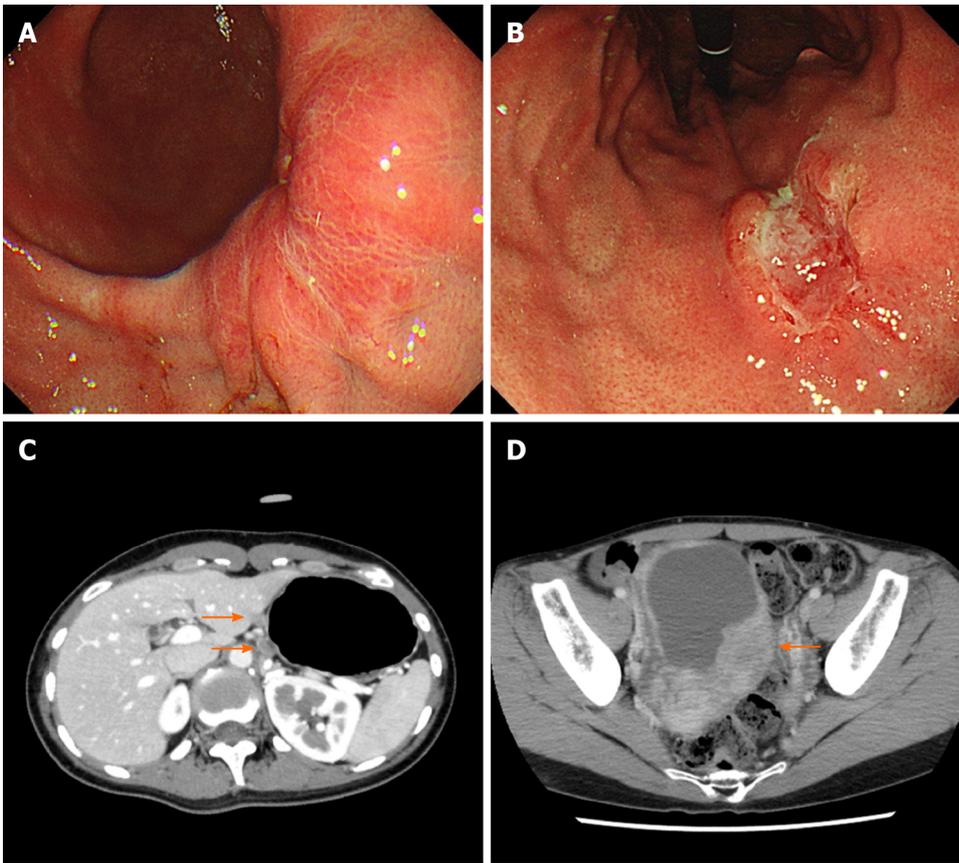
Representative images obtained from esophagogastroduodenoscopy and computed tomography in Case 1. A and B: Advanced gastric cancer was observed at the posterior wall of the lower gastric body (A) and at the lesser curvature of the middle body (B) in esophagogastroduodenoscopy; C: Metastatic lymph nodes were detected at the lesser curvature of the proximal stomach by abdominal computed tomography (CT) (orange arrows); D: Abdominal CT showed ovarian metastasis during adjuvant chemotherapy (orange arrow).
